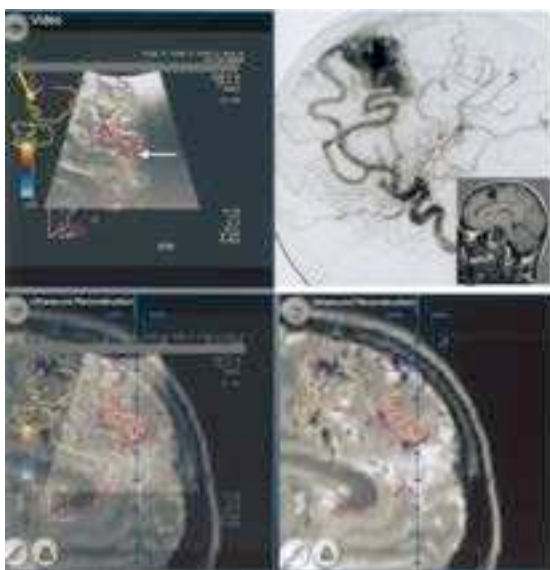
Intraoperative screenshot during surgery on a frontal AVM. The duplex color demonstrates the flow inside the feeder (white arrow). The arterial origin of this vessel is confirmed by an acoustic Doppler control (white arrow). Lower right, The screenshot shows the reconstructed MRI plane according to the ultrasound plane (upper left). Landmarking of the feeder has already been performed according to the ultrasound data. Note the red circled dots highlighting the feeder. Lower left, Image composition of the upper left and lower right images.
